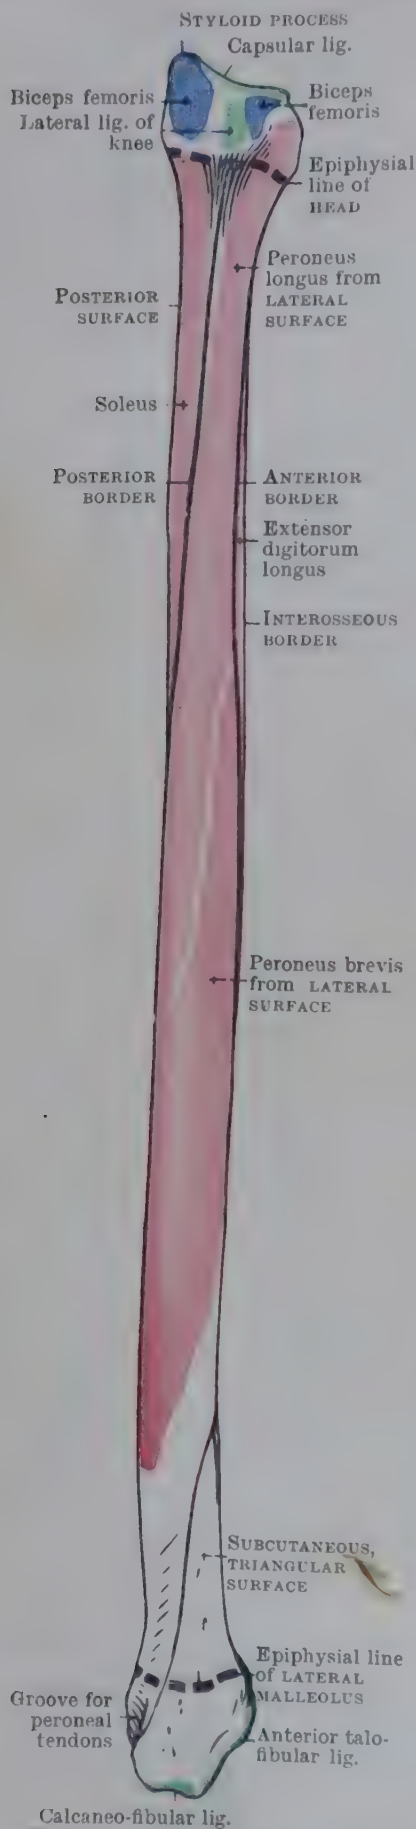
LATERAL ASPECT OF RIGHT FIBULA.
